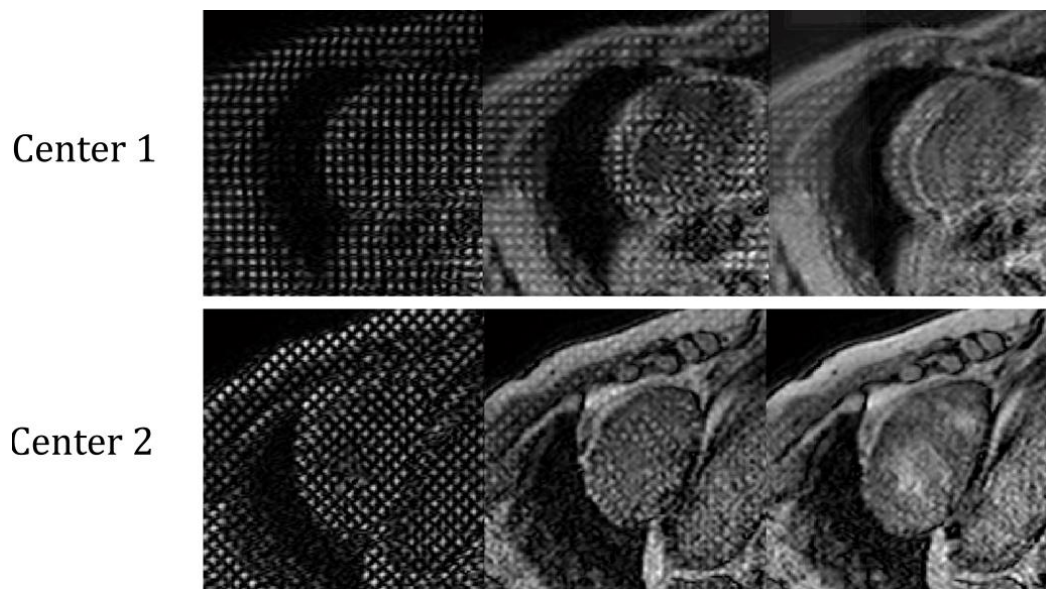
t-MRI acquired in two different centers.
